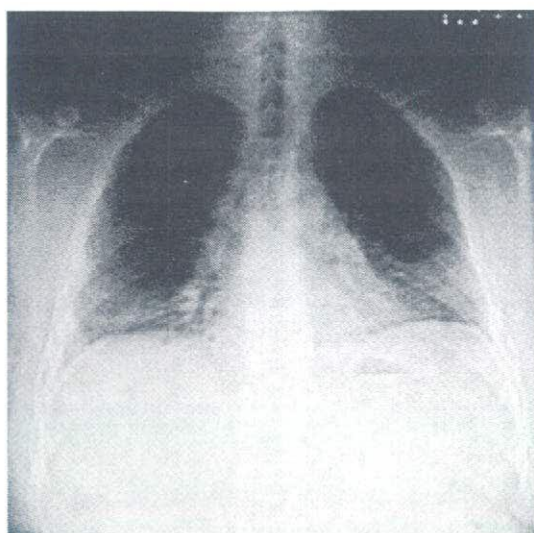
Chest radiograph on the first admission showed bilateral infiltrative shadows predominantly in lower lung field and suggested loss of lung volume.
